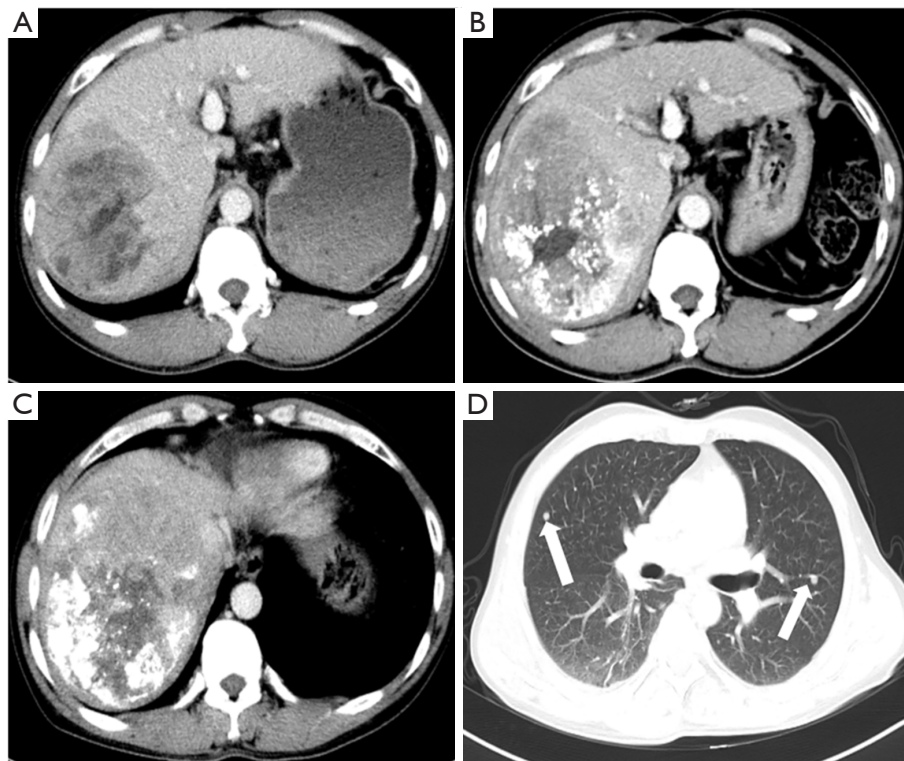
A 46-year-old male patient with hepatocellular carcinoma treated with TACE presented with TACE refractoriness after two consecutive TACE procedures. Baseline enhanced CT showed a 10.5-cm-sized tumor with heterogeneous enhancement (A). Follow-up enhancement CT after two TACE treatments showed a progressively larger and >50% surviving tumor (B,C) with bilateral lung metastases (D, white arrows). TACE, transarterial chemoembolization; CT, computed tomography.
